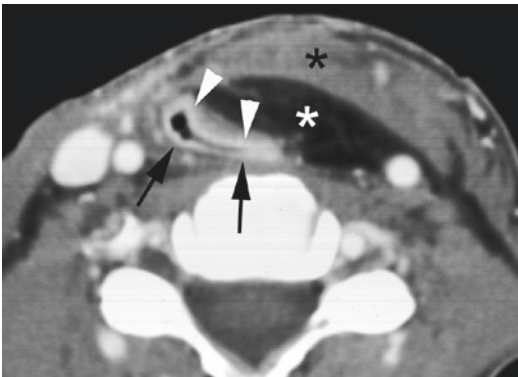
Axial contrast-enhanced CT image. Situation after total laryngectomy. The neopharynx is reconstructed by residual pharyngeal tissue (arrows) and a musculocutaneous soft tissue flap (pectoral major flap), containing skin (arrowheads), subcutaneous fat (black asterisk), and muscle (white asterisk)
